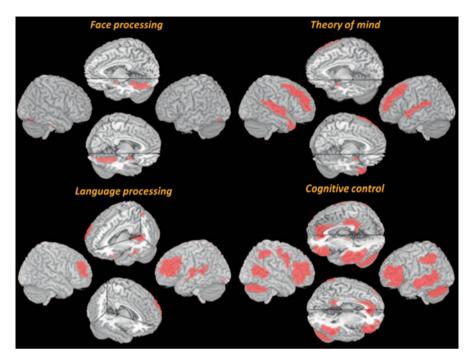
The figure shows brain network activations across studies and experimental manipulations in *ASD* compared to *TD* individuals, visualized on a 3D *MRI* template. Abnormal activation maps were modeled using an MRI-based atlas, showing regions reported to be involved in specific tasks. See text for further explanations
